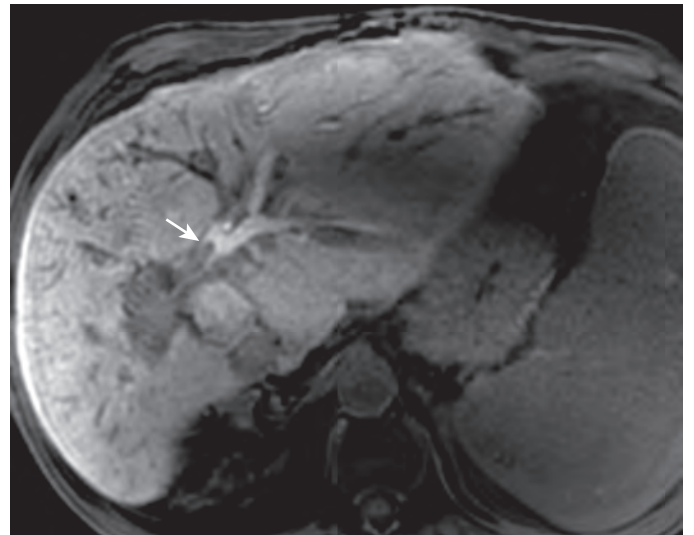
Biliary nonanastomotic stricture. Delayed hepatocyte phase MRI with use of hepatobiliary contrast agent (Gd-EOB-DTPA). Excreted contrast material in the biliary duct shows an ischemic biliary hilar stricture (arrow).
